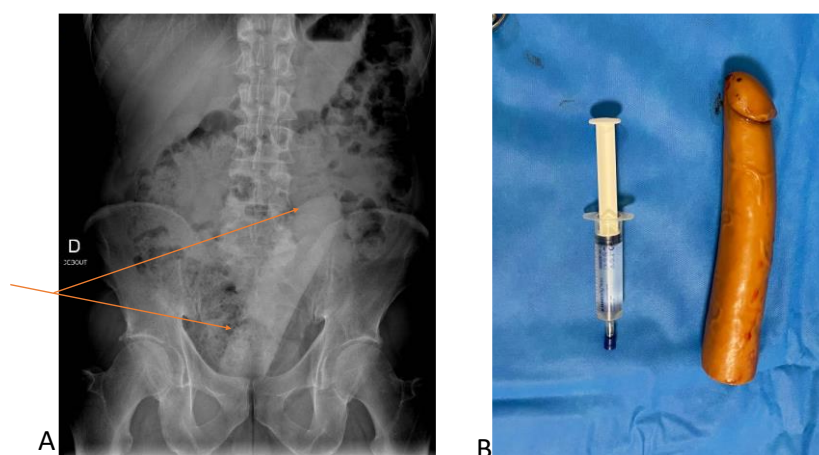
(Case 1) Radiographic evaluation and macroscopic outcome of a retained radiopaque rectal foreign body. (A) Upright anteroposterior plain abdominal radiograph demonstrating a vertically oriented radiopaque structure projecting over the rectosigmoid region (arrows). (B) Macroscopic appearance of the intact synthetic device following successful transanal extraction in the operating room.
